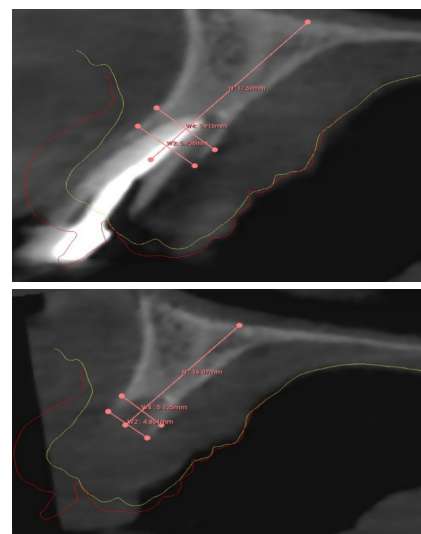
3D Slicer Software Analysis of Bone Dimension Changes in Pre and Postoperative CBCT Scans.
